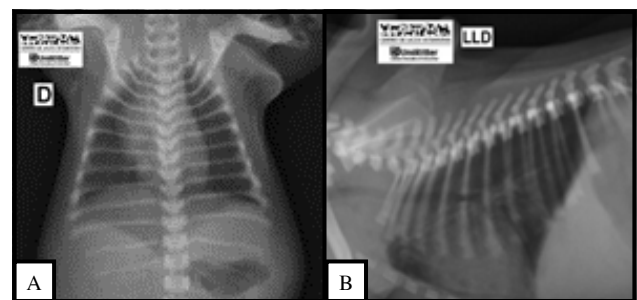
Thoracic radiograph taken to assess possible metastasis, showing changes in the cardiac silhouette and pulmonary fields, suggesting an inflammatory process.
